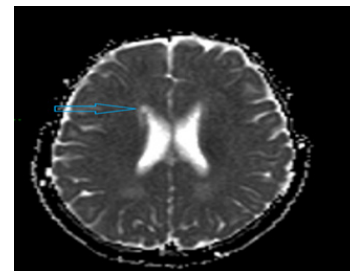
The MRI brain scan T2-weighted image showed a small sub-ependymal cyst (6.1 x 5.6 x 5.7 mm) attached to the upper border of the frontal horn of the right lateral ventricle that showed similar CSF signal intensity in all sequences with no mass effect (November 2019).
